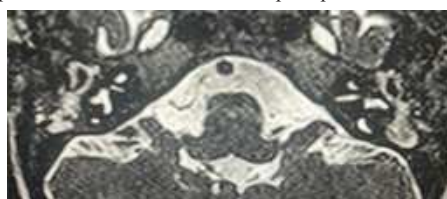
MRI CISS image show hypoplastic bilateral lateral semicircular canal
